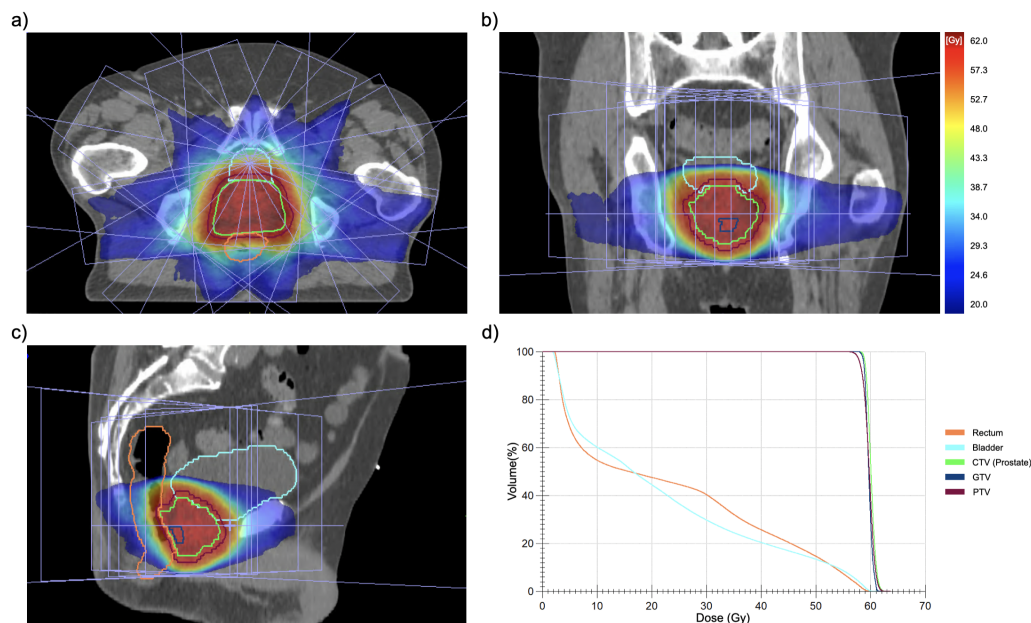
3D dose planning based on a CT image a) axial, b) coronal c) sagittal view, and d) DVH of the contour's rectum, bladder, CTV, GTV and PTV. The nine beams 25°, 60°, 100°, 135°, 180°, 225°, 260°, 300° and 340° are presented in purple in all three views.
